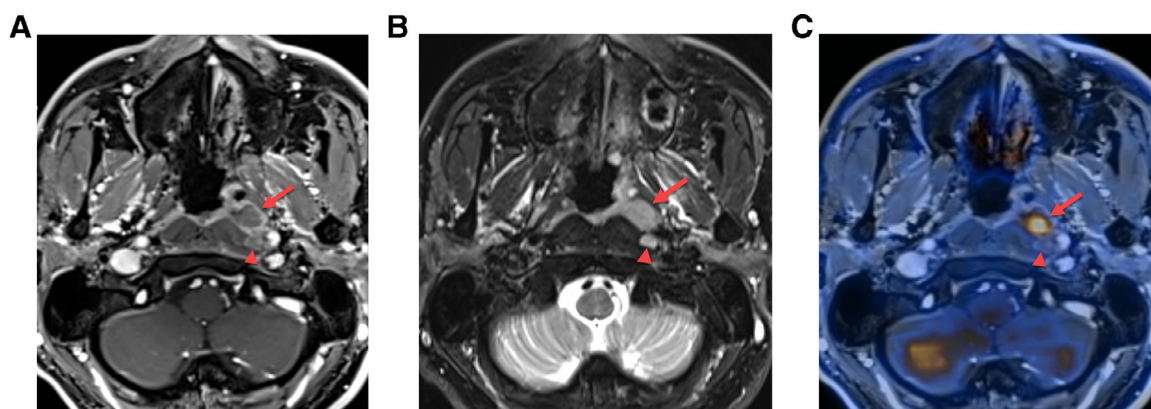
Nasopharyngeal carcinoma. The FDG-avid tumor (arrow) arises in the left-sided fossa of Rosenmüller, as seen on the axial contrast-enhanced T1-weighted fat-suppressed MR image (A), T2-weighted fat-suppressed MR image (B) and fused PET/MR image (C). No infiltration of the prevertebral space by the primary tumor is seen. However, a T2-hyperintense, FDG-negative lateral retropharyngeal lymph node metastasis (arrowhead) is seen adjacent to the prevertebral muscles, rendering the patient ineligible for surgery.
